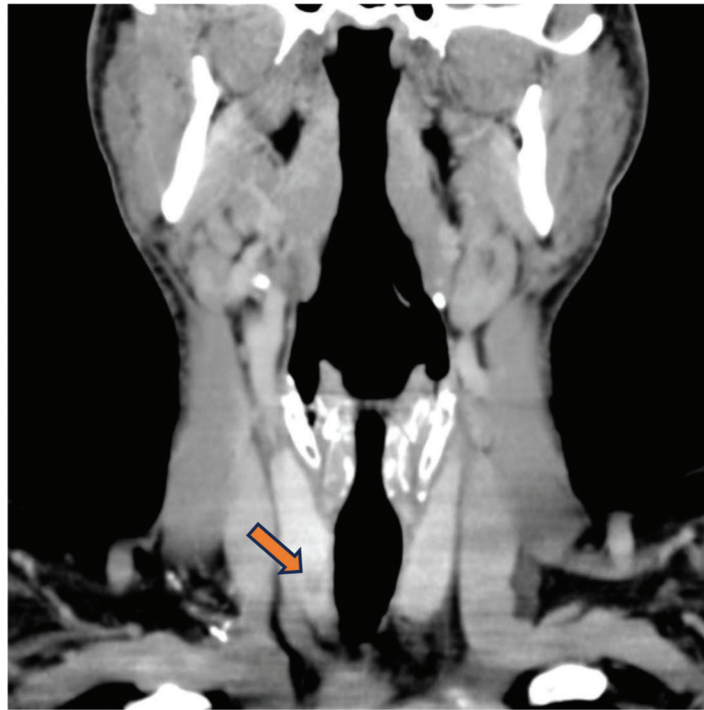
Neck CT (coronal view). A small hypodense nodule in the right thyroidal lobe (arrow).
